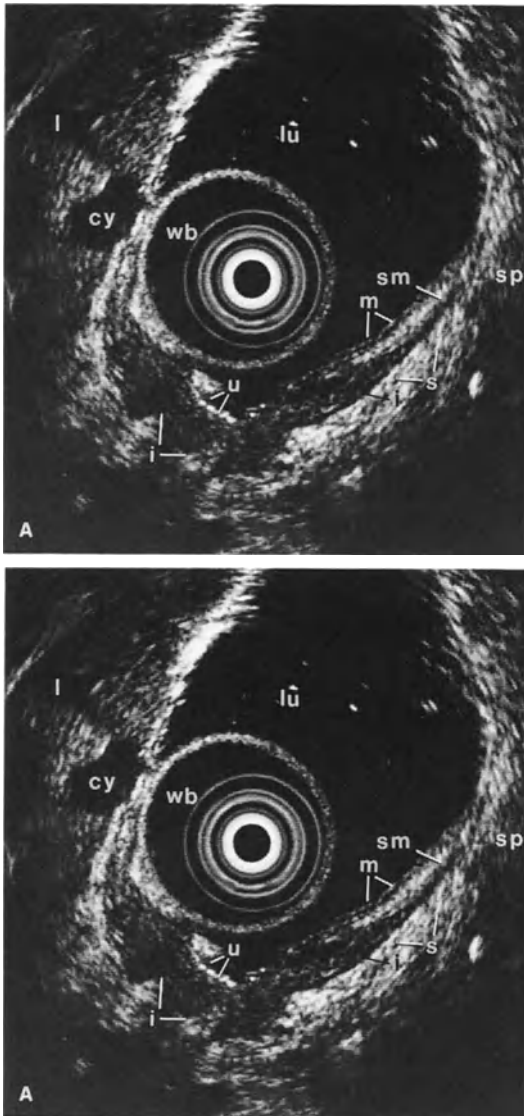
A, B. Endoscopic sonograms. A Ulcerative lesion (*u*) with transmurular infiltration (*i*) adjacent to the left liver lobe (*l*), proven to be benign by biopsies. *cy*, cystic lesion; *m*, mucosa; *sm*, submucosa; *sp*, spleen; *lu*, lumen. B Hypoechoic infiltration (*i*) penetrating into the muscularis propria (*mp*) adjacent to an extensive ulcer (*u*), proven to be non-Hodgkin lymphoma
